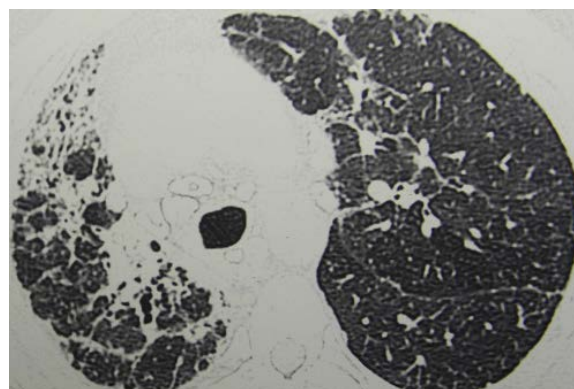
Chest x-ray showing progressive scarring and volume loss associated with fibrosis mainly on the right lung
